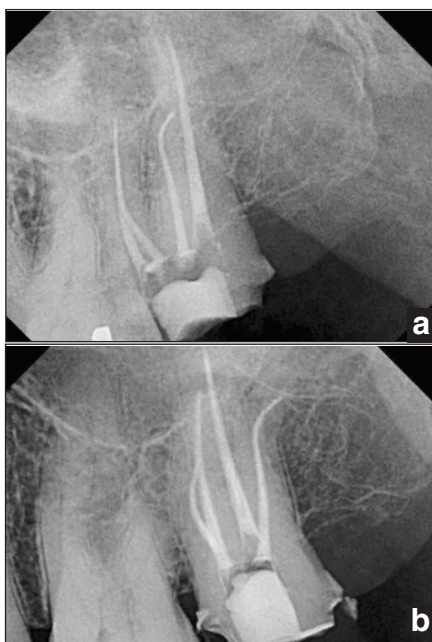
Pre- and post-op radiographs of a case initially obturated with Activ GP and BC Sealer and then retreated and obturated with the same technique. Courtesy of Dr. Ali Nasseh, Boston.
